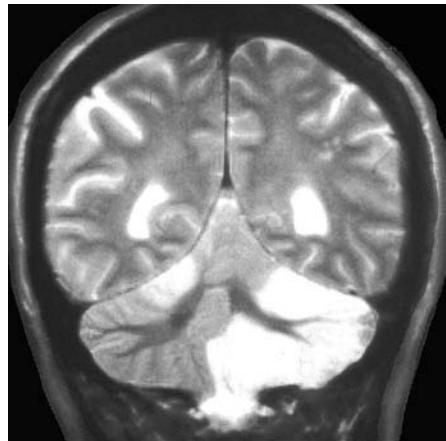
T2-weighted MRI showing the characteristic broadening of the cerebellar cortex (hyperintense signal) on the right side, with a smaller focus in the left cerebellar hemisphere. From Sonier *et al.* {2123A}.
